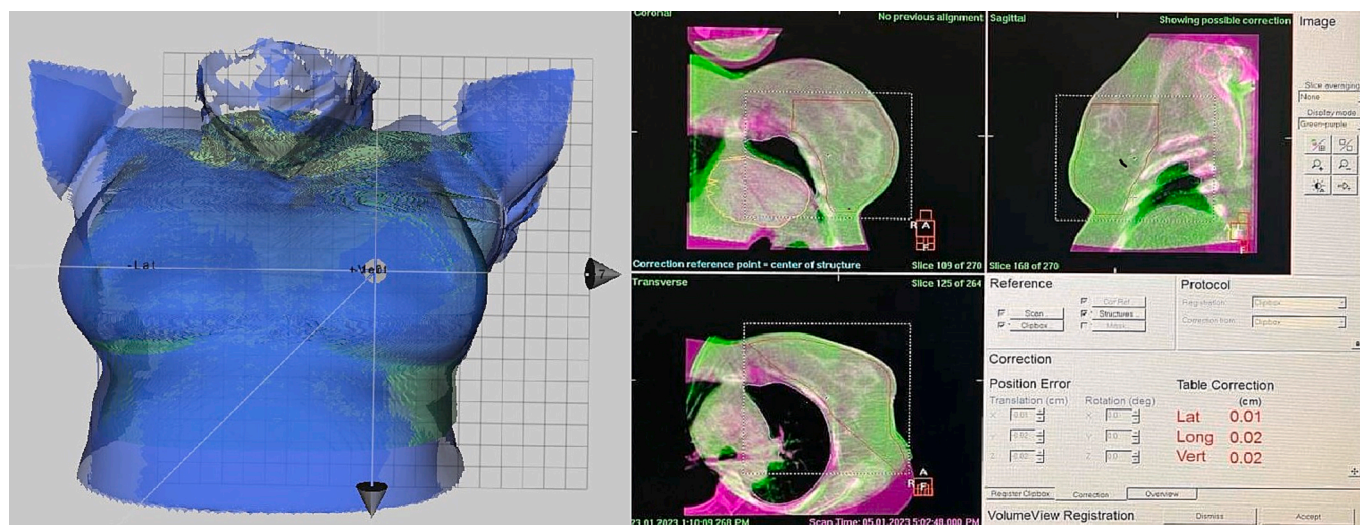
Matching a planned and live surface position reference with Catalyst HD+ (left) and the CBCT match of a tattoo-less breast only case on XVI (right).
